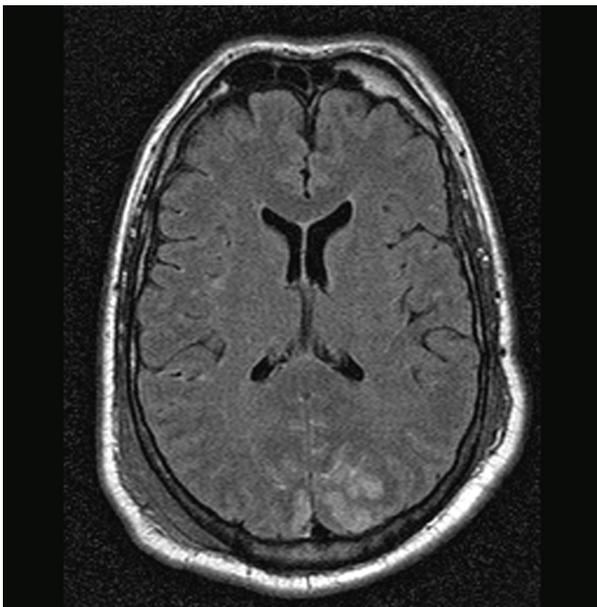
Axial images of brain magnetic resonance imaging of the patients demonstrating ischemia of the both occipital cortex (primary visual cortex) resulting in cortical blindness.
